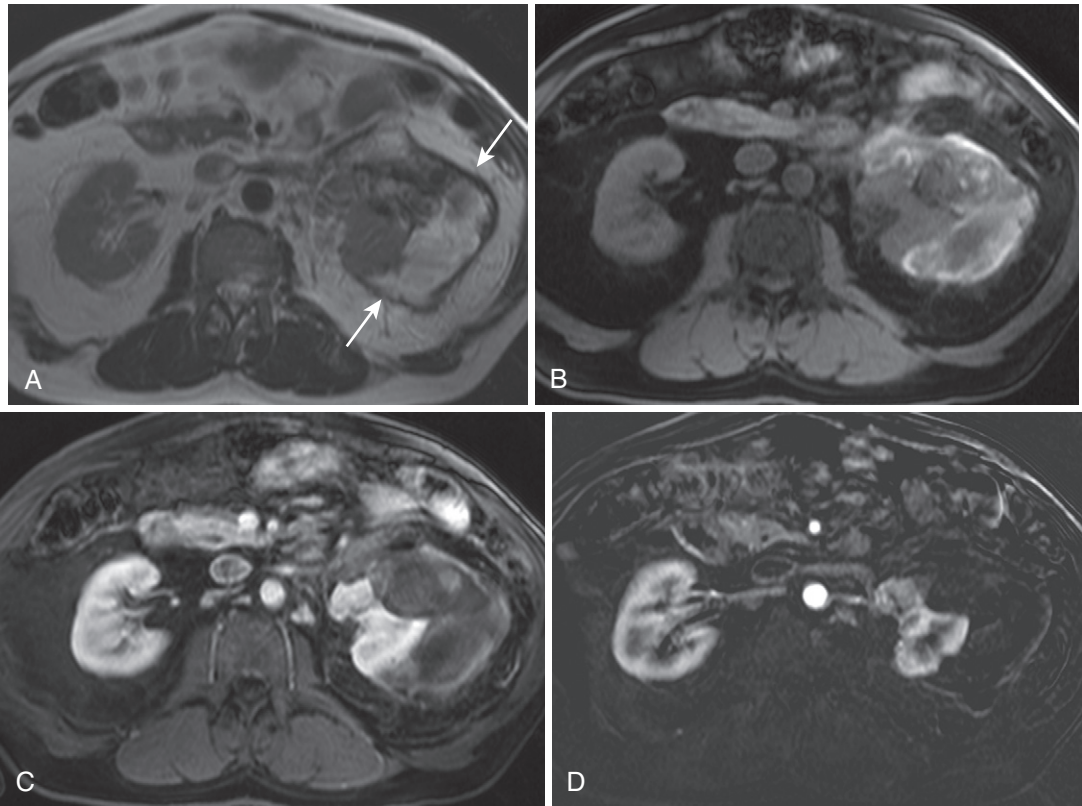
Renal hematoma. A large left perinephric collection (*arrows* in A) demonstrates heterogeneous hyperintensity on the T2-weighted image (A) with corresponding hyperintensity on the T1-weighted fat-suppressed image (B). The postcontrast image (C) shows mild intralésional hyperintensity not corresponding to enhancement, proven by the lack of signal on the subtracted image (D).
